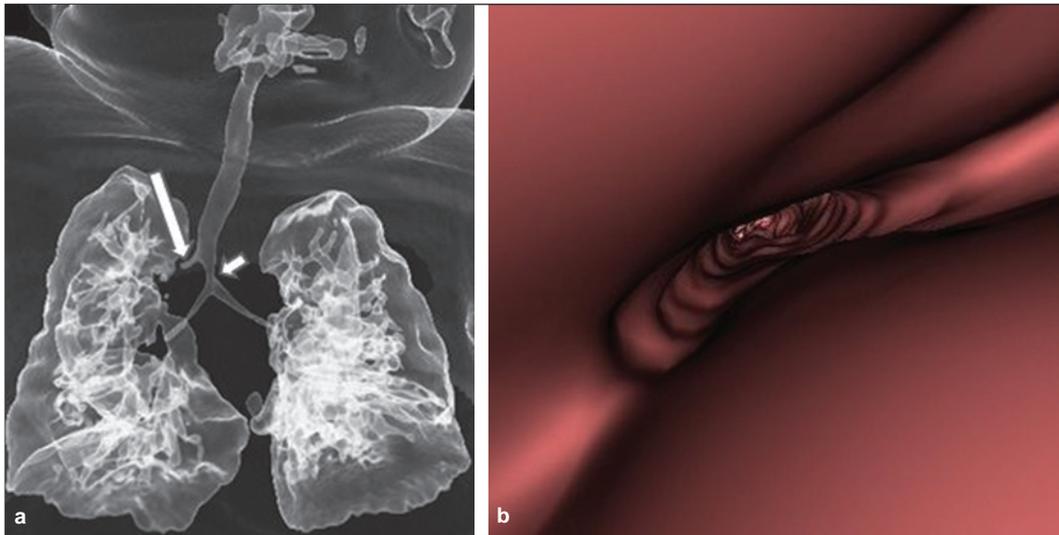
(a) Coronal 3D volume-rendered CT image showing distal tracheal luminal narrowing (short arrow) and a right upper lobe bronchus arising from the supracarinal trachea (long arrow); (b) virtual bronchoscopy image showing the partially collapsed tracheal lumen suggestive of tracheomalacia
